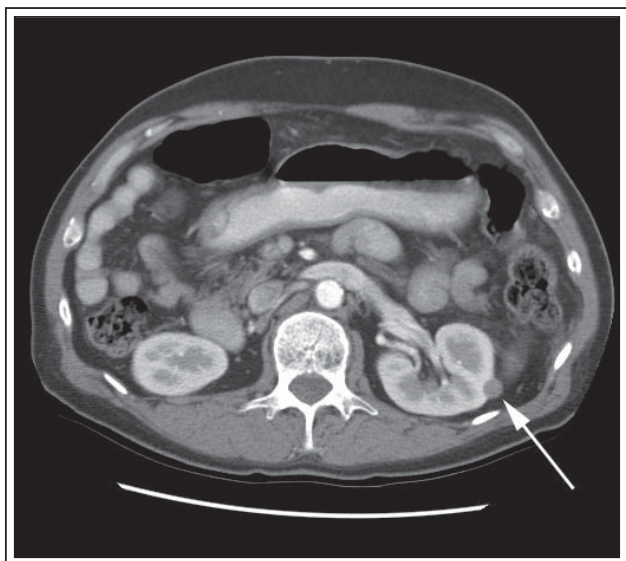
Contrast CT of abdomen and pelvis showing 1.3 cm left mid-pole renal mass.
